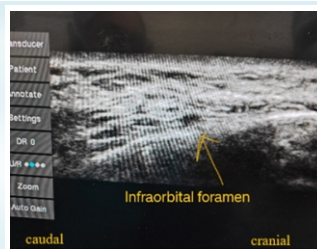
Ultrasound image of infraorbital foramen
